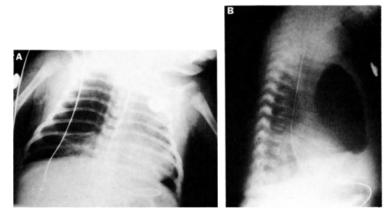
Posteroanterior and lateral chest radiographs in a newborn with respiratory distress. There is a hyperlucent right hemithorax with slight shift of the mediastinum to the left. On the lateral view, a large lucent
